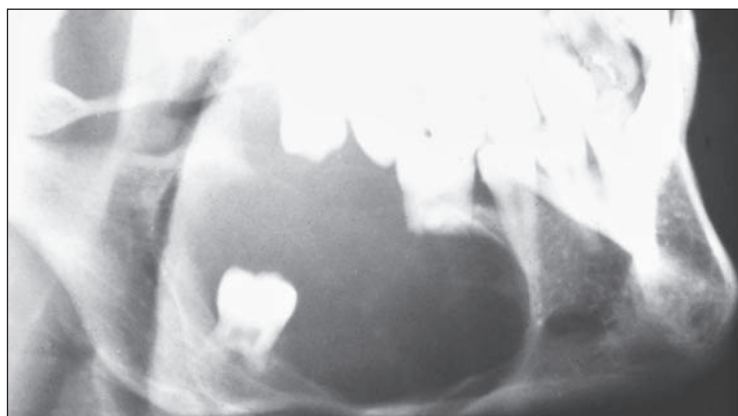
Radiograph of a central type of dentigerous cyst. Note resorption of the root of the first mandibular molar. (Courtesy the late Professor J.J. Pindborg.)
